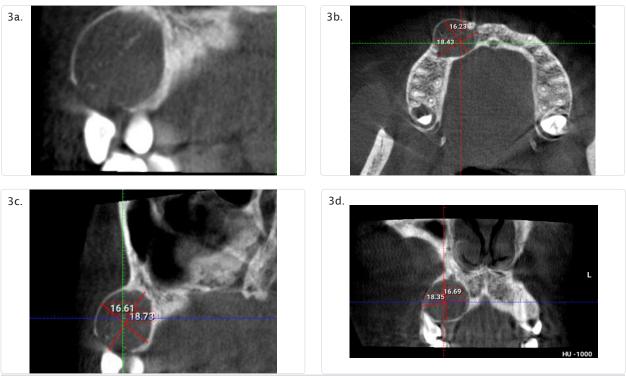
CBCT images showing maximum size of the lesion on different planes- (a) sagittal section showing foci of calcifications (b) axial section (c) sagittal section (d) coronal section.
